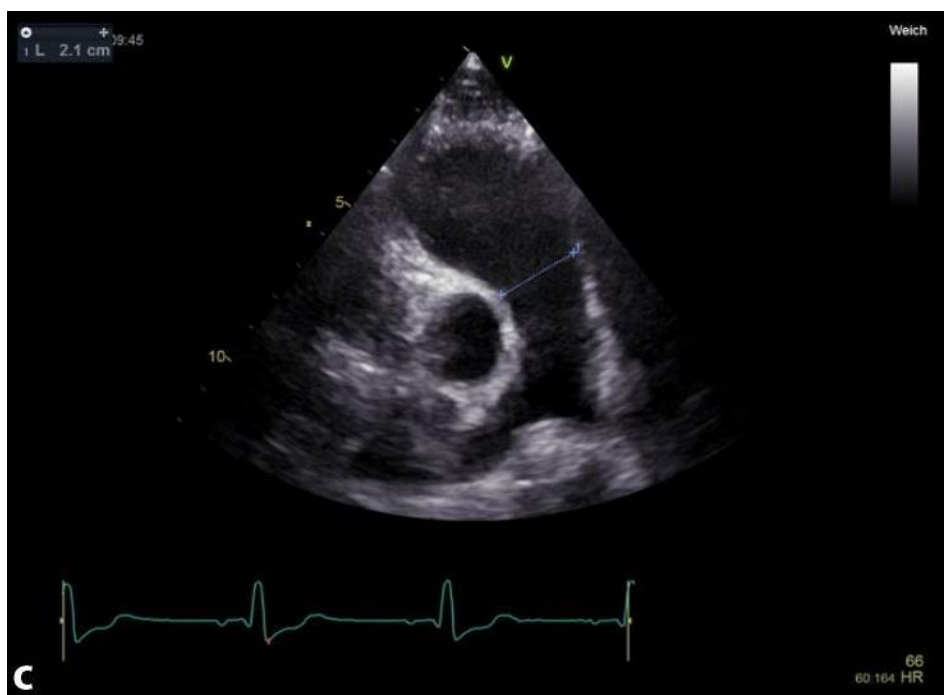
Distal right ventricular outflow tract on parasternal short-axis view (normal range 17-27mm).
